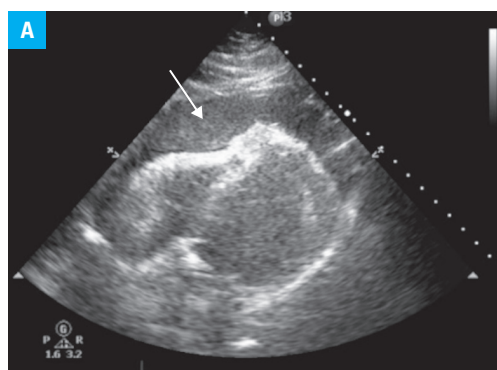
Echocardiography showing pericardial effusion (arrow) due to free-wall rupture (A); chest X-ray showing pericardiocentesis (arrow) and chest compression with the Lucas2 system (arrows) (B)
